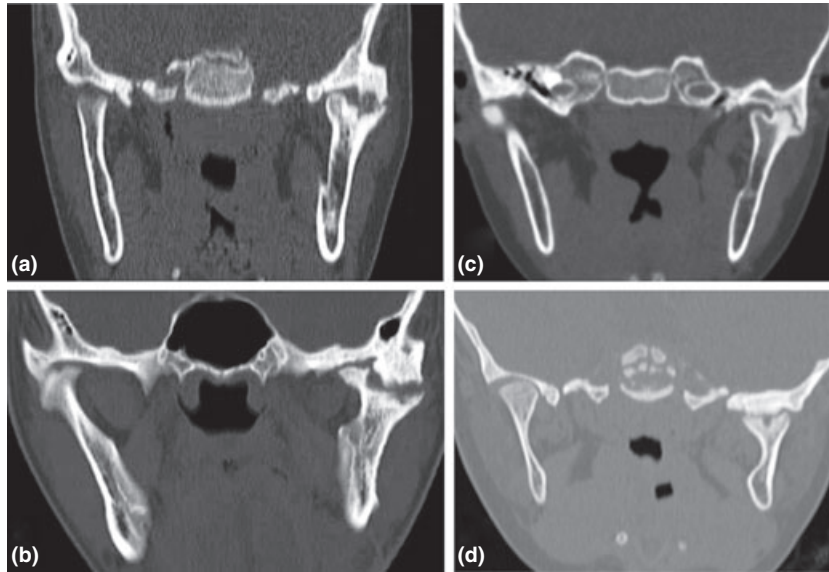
CT of present case series. A, C: CT of cases with left side TMJ ankylosis and left BMC oriented mesio-distally with lateral head ankylosed. B, CT of a case with bilateral TMJ ankylosis and right BMC oriented mesio-distally with lateral head ankylosed. D, CT of a case with left side TMJ ankylosis and left BMC oriented Mesio-laterally with medial head ankylosed (CT, Computed Tomogram; TMJ, Tempromandibular Joint; BMC, Bifid Mandibular Condyle).
